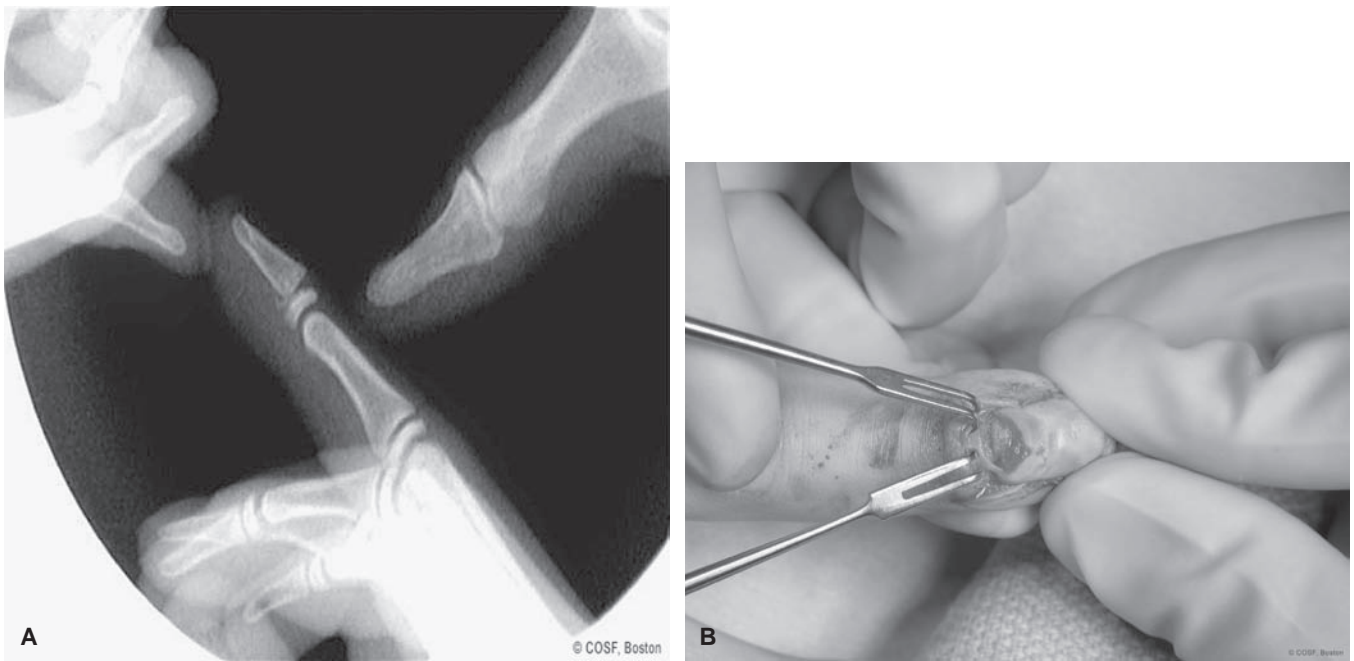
Seymour's fracture. A: Lateral radiograph depicting a displaced distal phalangeal physeal fracture in the setting of a nail bed injury. B: Intraoperative photograph after nail plate removal depicting the tear in the germinal matrix of the nail bed and underlying bony injury. (Courtesy of Children's Orthopaedic Surgery Foundation.)
